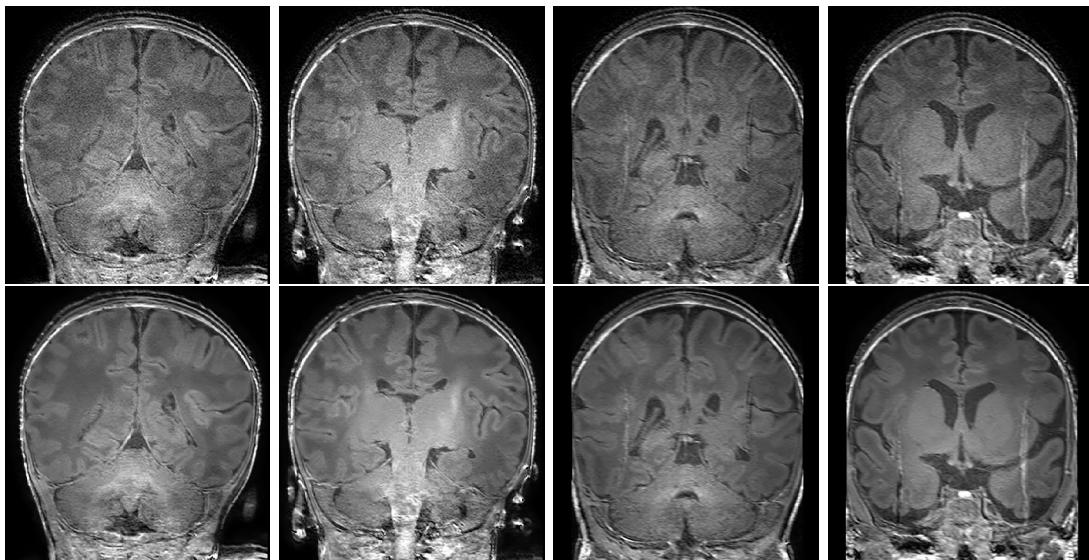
Visualization of the denoised effect on ANR MAIA dataset. The first row shows the raw T1w MR image; the second row presents the application of denoised algorithm.
